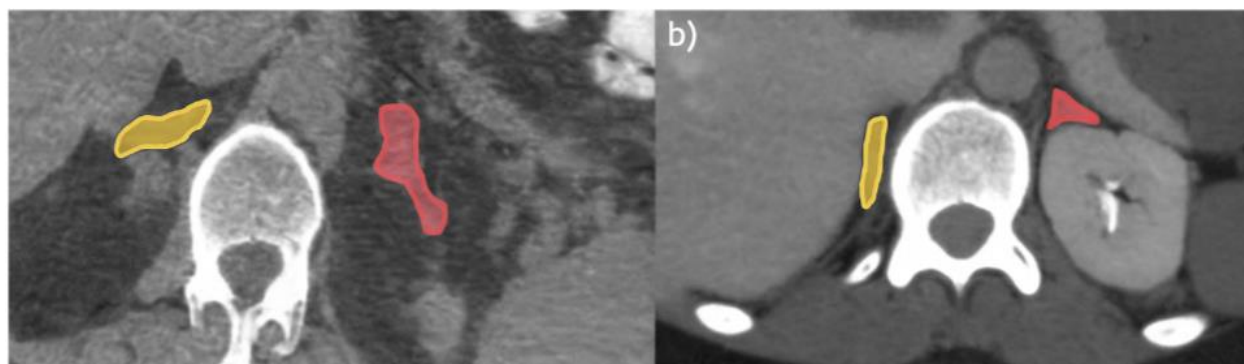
e 2. Segmentation of the adrenal glands. Computed tomography: the right adrenal gland is highlighted in yellow, and the left adrenal gland in red. AGV: Adrenal gland volume. Source: Stepansky et al., 2025 [9].
